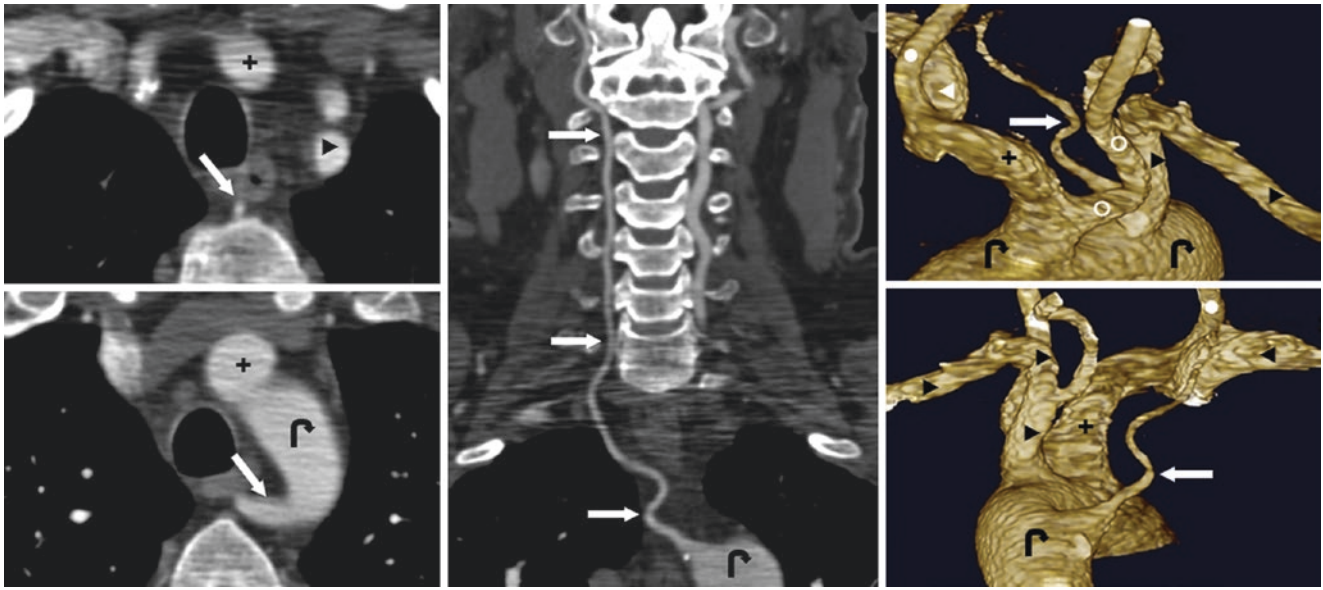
54-year-old with a left arch, an IA/LCCA common origin, and a distal, aberrant, retroesophageal right vertebral artery (RVA) (arrows) on CTA axial views (left), coronal curved MPR view (middle), and on 3D VR AP (right, top) and posterior (right, bottom) views (Courtesy of Jeff Brace, MD, Suburban Radiologic Consultants, Edina, MN.). *Aortic Arch* (curved arrows); *IA* Innominate Artery (+); *LCCA* Left Common Carotid Artery (○); *LSCLA* Left Subclavian Artery (▶); *RCCA* Right Common Carotid Artery (●); *RSCLA* Right Subclavian Artery (◄)
